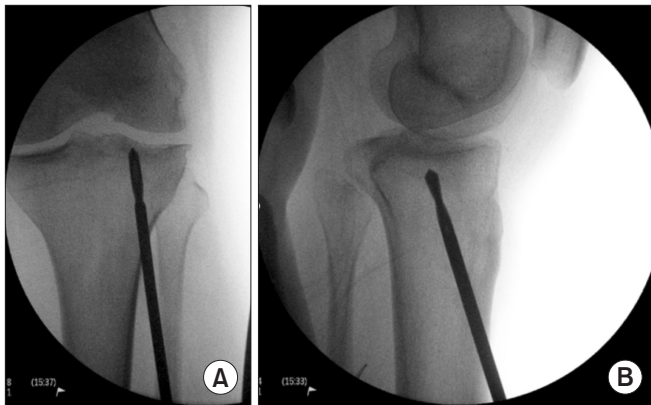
Core decompression radiographs: anteroposterior (A) and lateral (B).
